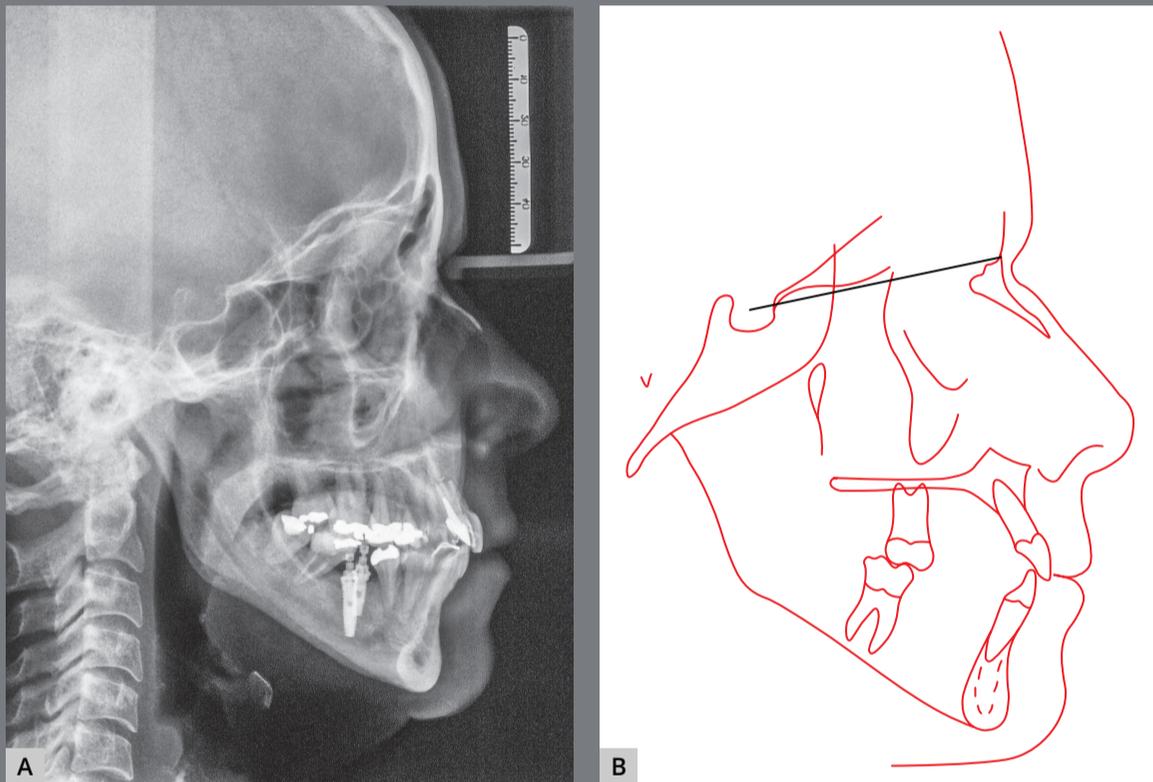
Cephalometric radiograph (A) and cephalometric tracing at the end of treatment (B).
